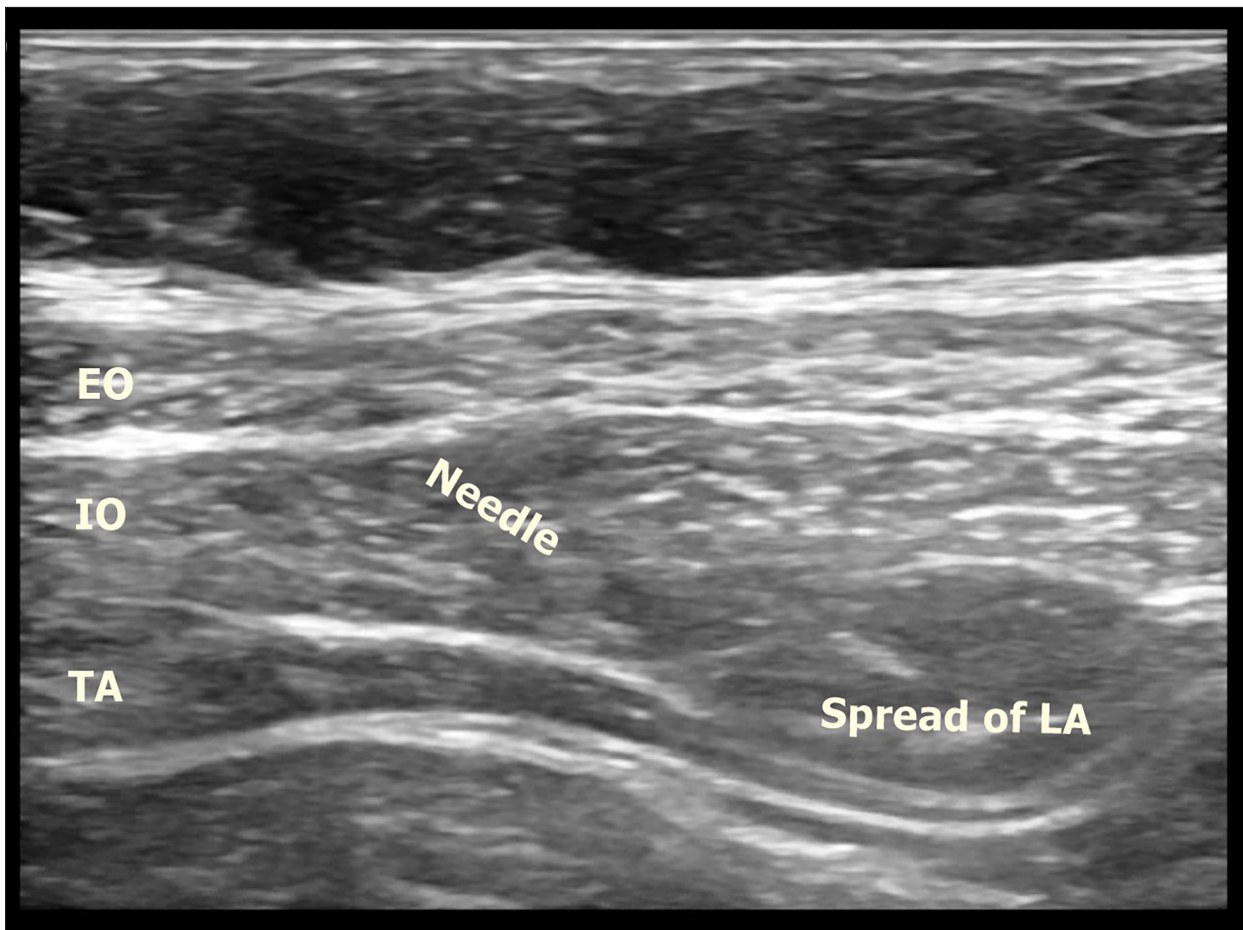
Sonographic anatomy of the subcostal transversus abdominis plane (TAP) block. The arrows indicate the needle direction. Abbreviations: Cc, costal cartilage; EO, external oblique; IO, internal oblique; TA, transversus abdominis; LA, local anesthetic.
